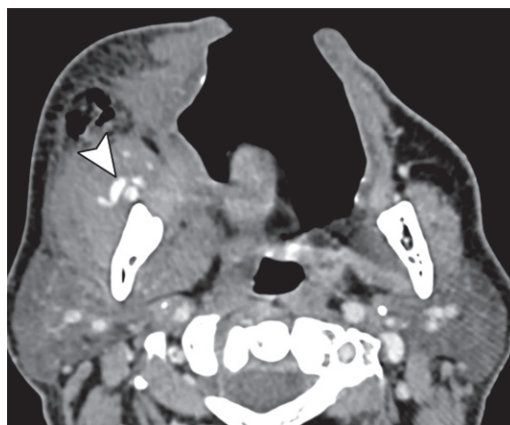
Hematoma with active bleeding. Axial contrast-enhanced CT image (soft-tissue window) after third molar extraction shows a large hematoma containing serpentine foci with enhancement (arrowhead).
